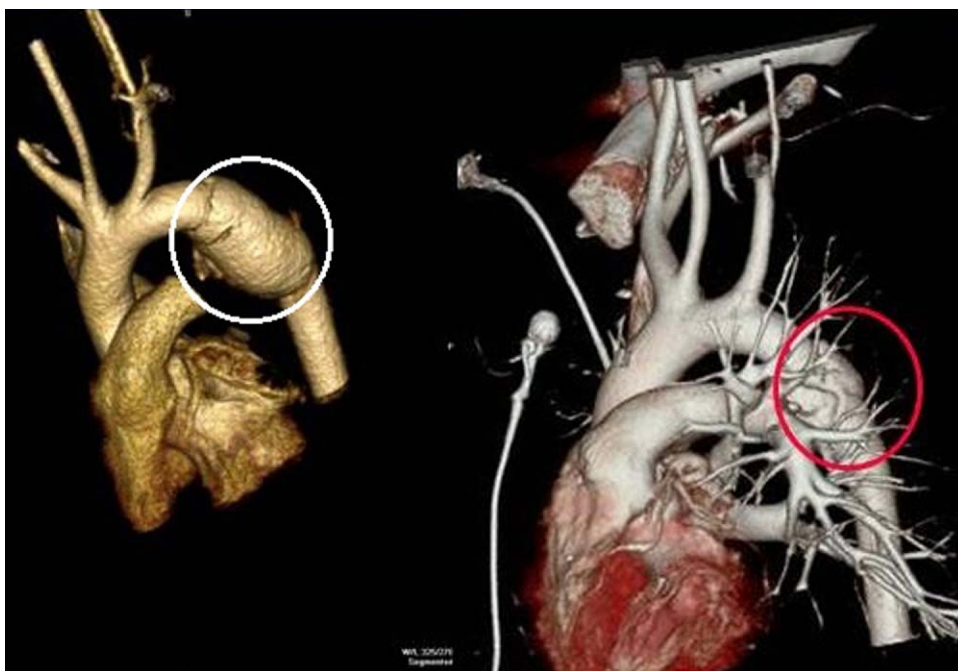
High-speed traffic injury. The mediastinum on the chest x-ray seems unremarkable. Routine CT scan shows an aortic injury (circle). Note the absence of any major periaortic hematoma, which explains the normal mediastinum on plain radiography.
